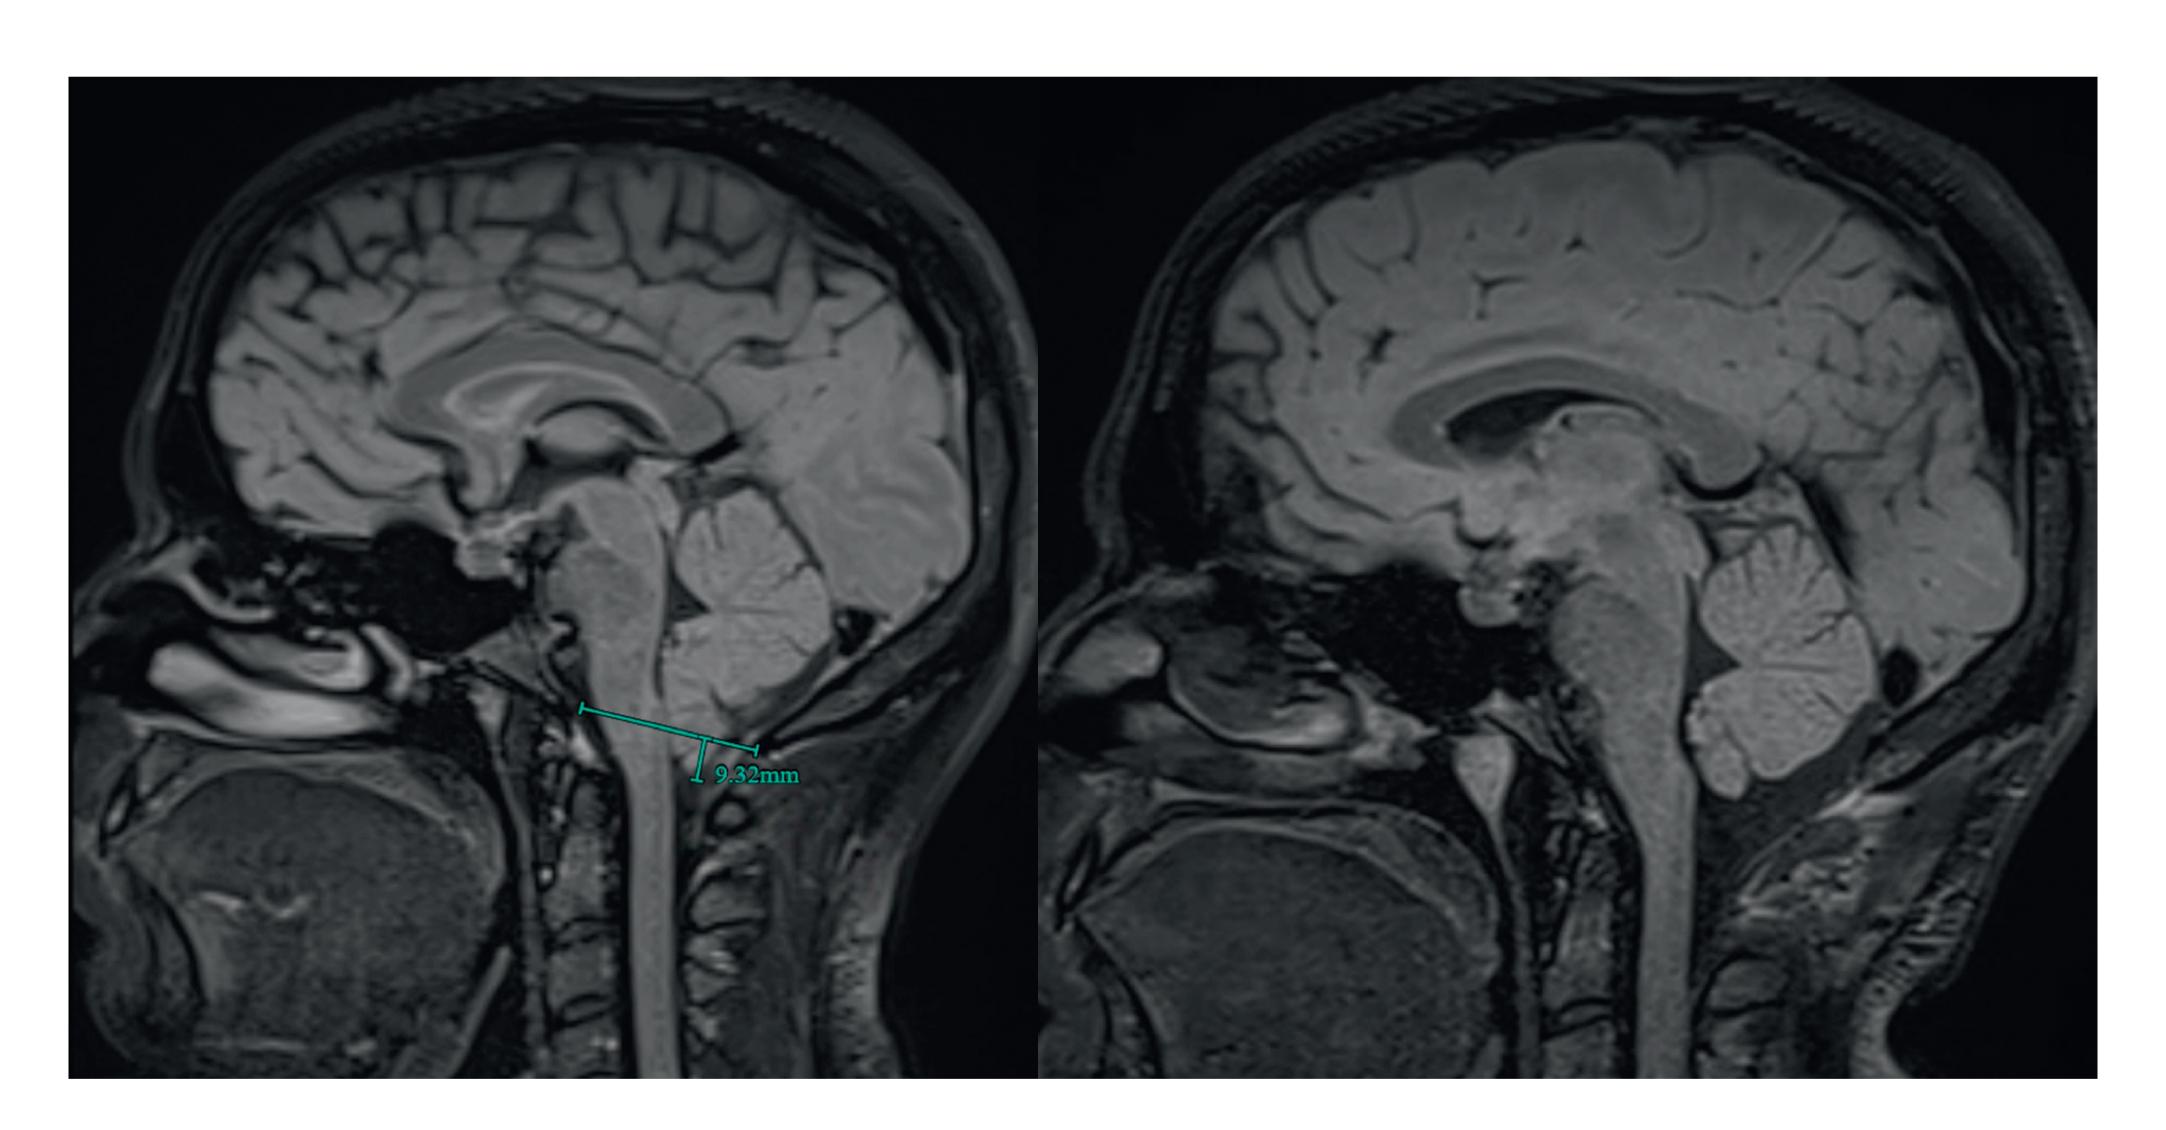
Preoperative MRI (T2 FLAIR) showing tonsillar herniation >9mm with compression of medulla oblongata. There was no hydrocephalus or syringomyelia.
